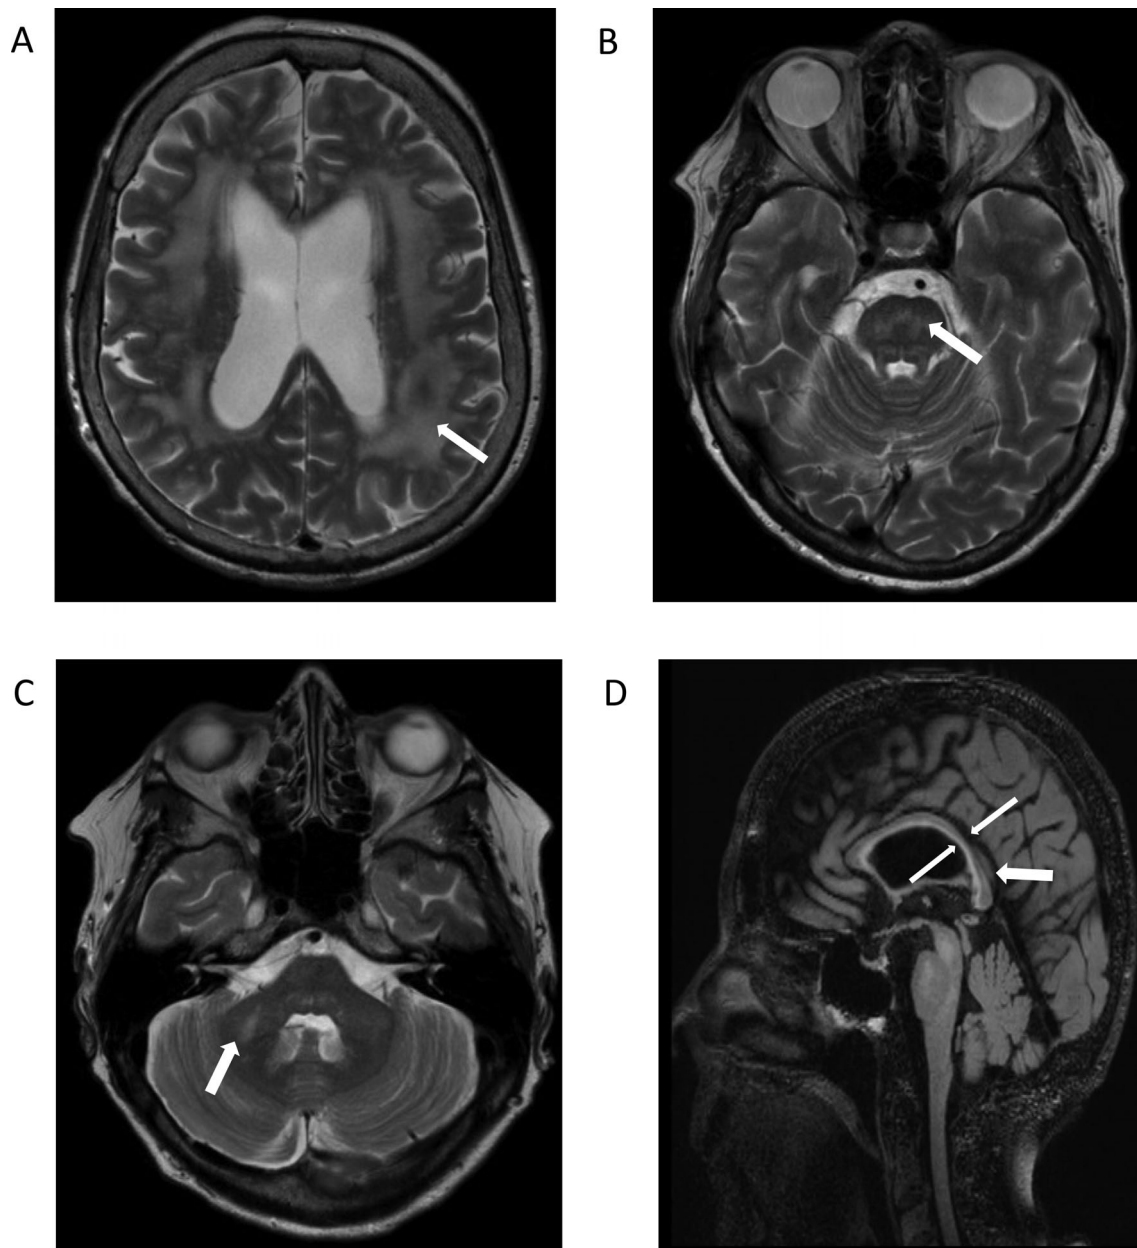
Overview of magnetic resonance imaging findings in selected women with fragile X-associated tremor and ataxia syndrome, white arrows pointing to region of interest. (A) Severely increased T2 signal intensity in the deep white matter of the cerebrum, especially in the periventricular regions. (B) Increased T2 signal intensity in the pons. (C) Increased T2 signal intensity in the middle cerebellar peduncles (sign). (D) Increased T2 signal intensity in the splenium of the corpus callosum and a general thinning of the corpus callosum.
